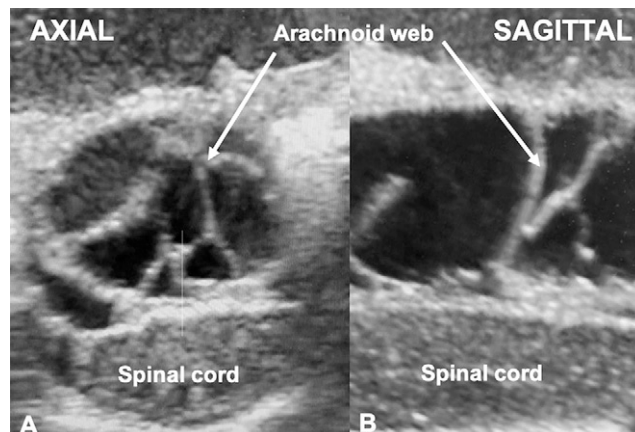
Intraoperative ultrasound. A and B: There is significant upper thoracic cord anterior displacement by a complex network of arachnoid membranes (arrows). Internal echoes within CSF suggest impaired flow.
